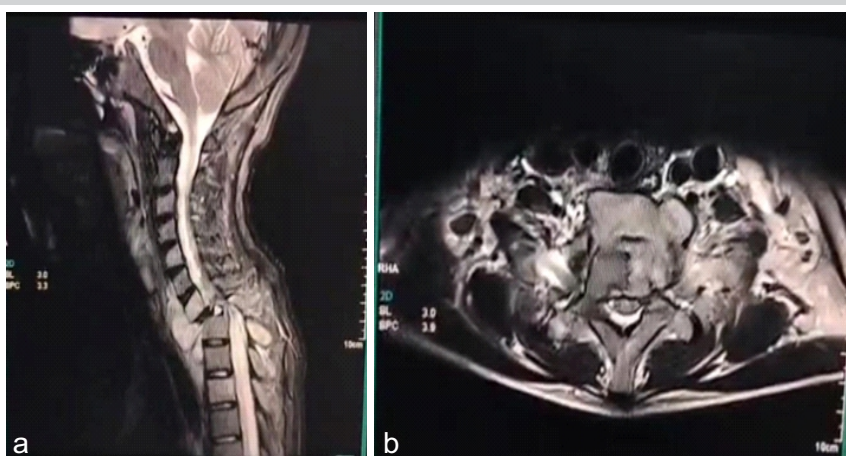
(a and b) Magnetic resonance imaging sagittal image showing spinal cord compression due to epidural and prevertebral abscess at the cervicodorsal junction.
